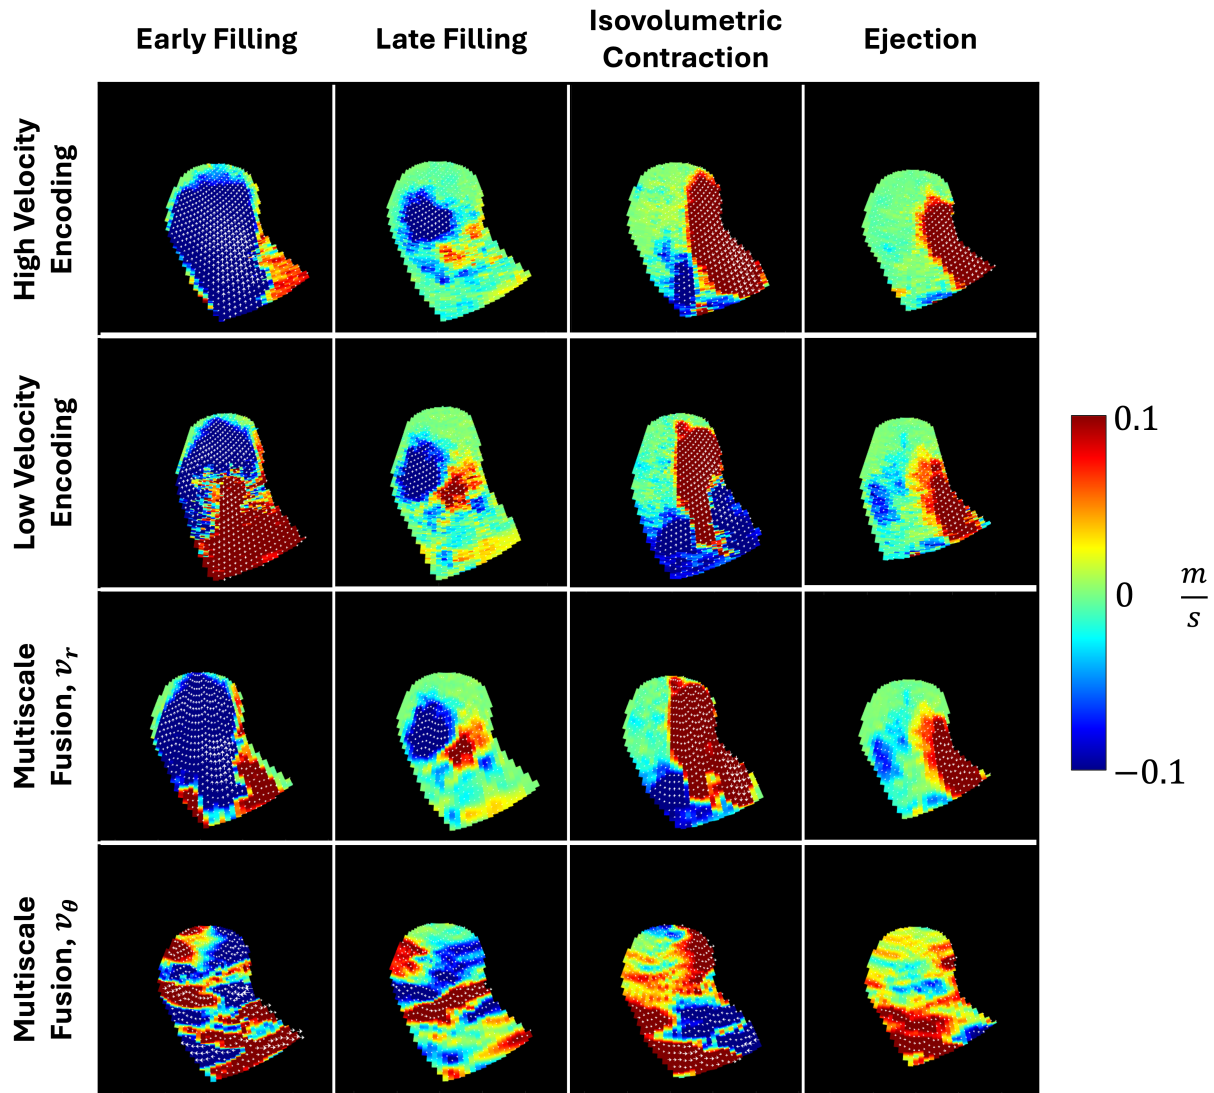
Doppler Multiscale Fusion at four key points in the cardiac cycle: early LV filling, late LV filling, isovolumetric contraction, and ejection. Rows 1 and 2 show color Doppler acquisitions obtained with high (0.66 m/s) and low (0.33 m/s) velocity encodings, respectively. Rows 3 and 4 present the corresponding radial and azimuthal velocity fields reconstructed using the Multiscale Fusion VFM method.
